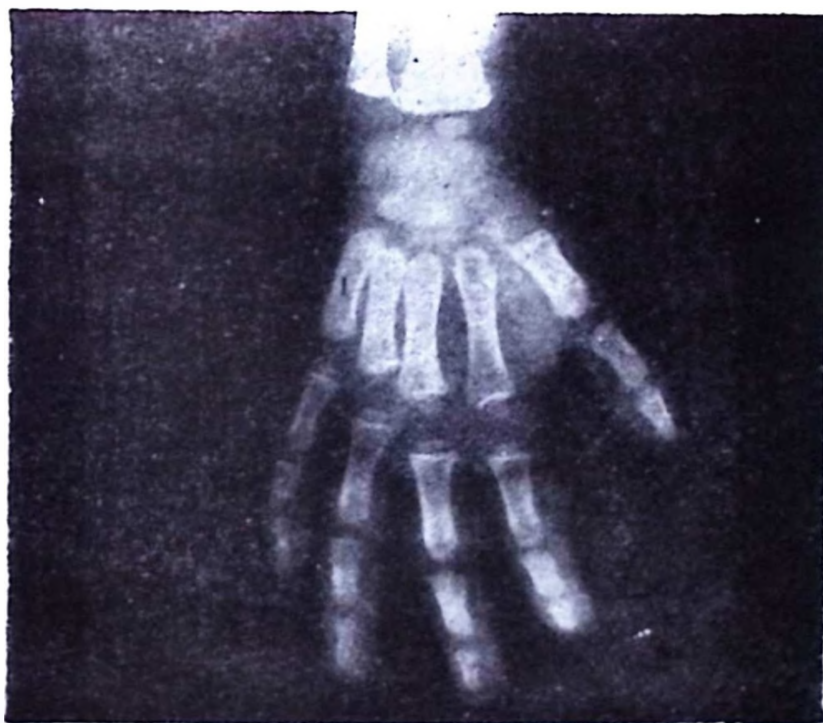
X-ray of the hands showing soft tissue swelling in the phalanges (Case 1).
